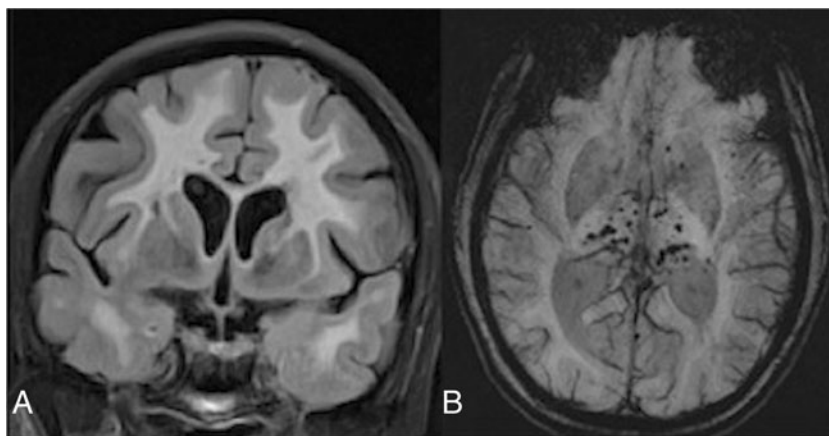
A patient with proven CADASIL. Coronal FLAIR image (a) shows widespread and confluent white matter hyperintensities with involvement of the external capsules and temporal lobes bilaterally. The susceptibility-weighted (SWI) image shows multiple microhaemorrhages
